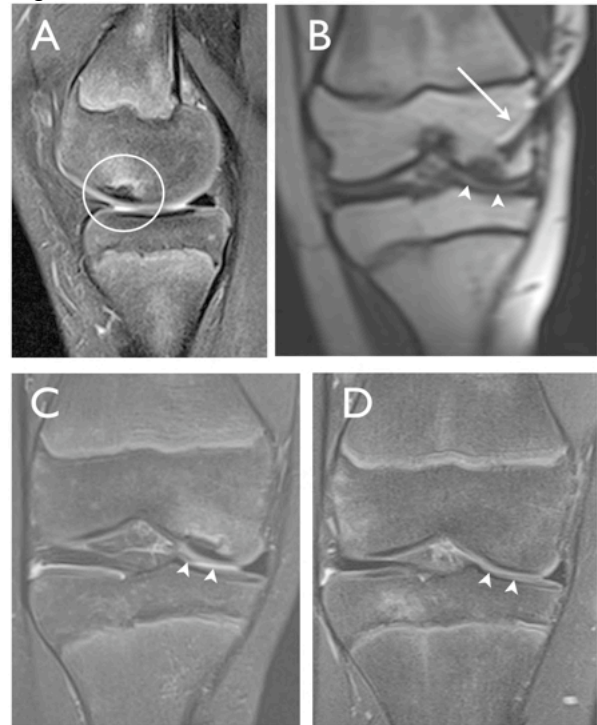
(a) A preoperative sagittal MRI image (1.5 T) depicting medial JOCD lesion (oval) of the femur. (b) A coronal intraoperative MRI (1.5T) image shows MRI guided drilling of the femoral OCD lesion. Drill appears as an oblique signal void (arrow) approaching the lesion with sclerotic margins (arrowheads).
